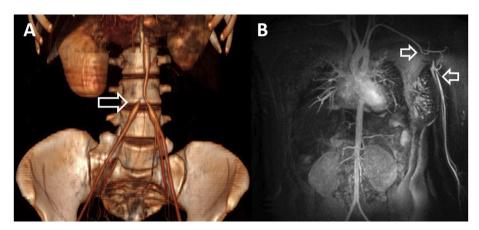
Computed tomography angiography three-dimensional reconstruction that reveals a stenotic lesion distal aorta, extending to the proximal common iliac arteries bilaterally with a total occlusive lesion at the origin of the right common iliac artery (white hollow arrow) (A). A magnetic resonance angiography assessed the entire aorta and its branches and revealed 3cm occluded segment in the left axillary artery (between two black hollow arrows) (B). Permission to reproduce Fig. 1B was granted by Elsevier. Hinojosa CA, Anaya-Ayala JE, Gomez-Arcive Z, et al. Eur J Vasc Endovasc Surg 2017; 54(3): 397–404.
